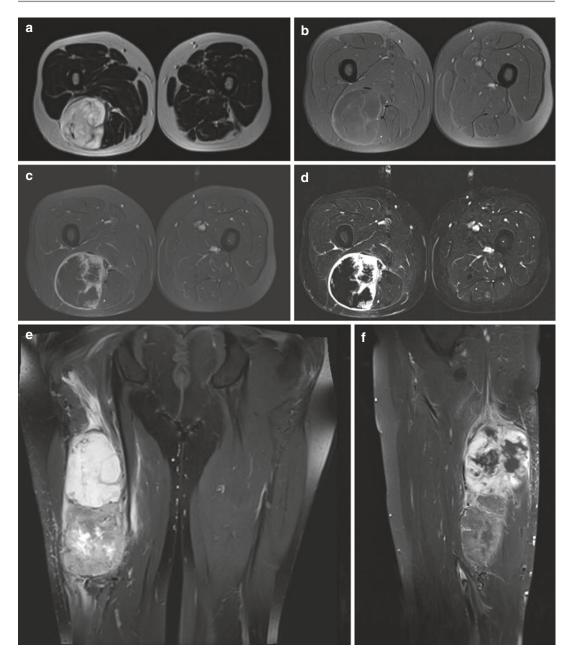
(a-f) Myxofibrosarcoma in a 49-year-old man. (a) Axial turbo spin-echo T2-weighted MR image. (b) Axial fat-saturated T1-weighted MR image after gadolinium contrast injection. (d) Axial subtraction of the pre- and post-contrast T1 MR images. (e) Coronal fatsaturated T2-weighted MR image. (f) Sagittal fat-saturated T1-weighted MR image after gadolinium contrast injection: Large oval-shaped lesion in the hamstrings compartment showing very high T2 signal intensities (a), T1 signal intensities lower than the muscle (b), and large areas of nonenhancement centrally (c, d), suggesting a large myxoid component. The lesion is ill-defined with some perifascial extensions (e, f) (Courtesy of F. M. Vanhoenacker, Belgium)
